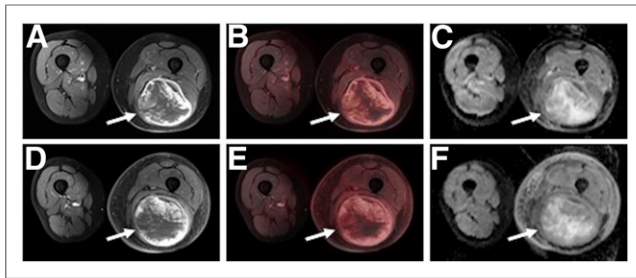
Images of 56-y-old patient with STS (leiomyosarcoma; arrows) of left upper leg. Tumor does not show SUV relevant change in size (+5.3%; A and C, MRI), metabolic activity (SUV_{peak} : -7.7%, B and E, PET/MRI), or diffusion restriction (ADC_{mean} : -5.1%, C and F, ADC map) on pretherapeutic (A–C) and posttherapeutic (D–F) PET/MR images and was classified as nonresponder (regression grade 5) after surgical resection.
